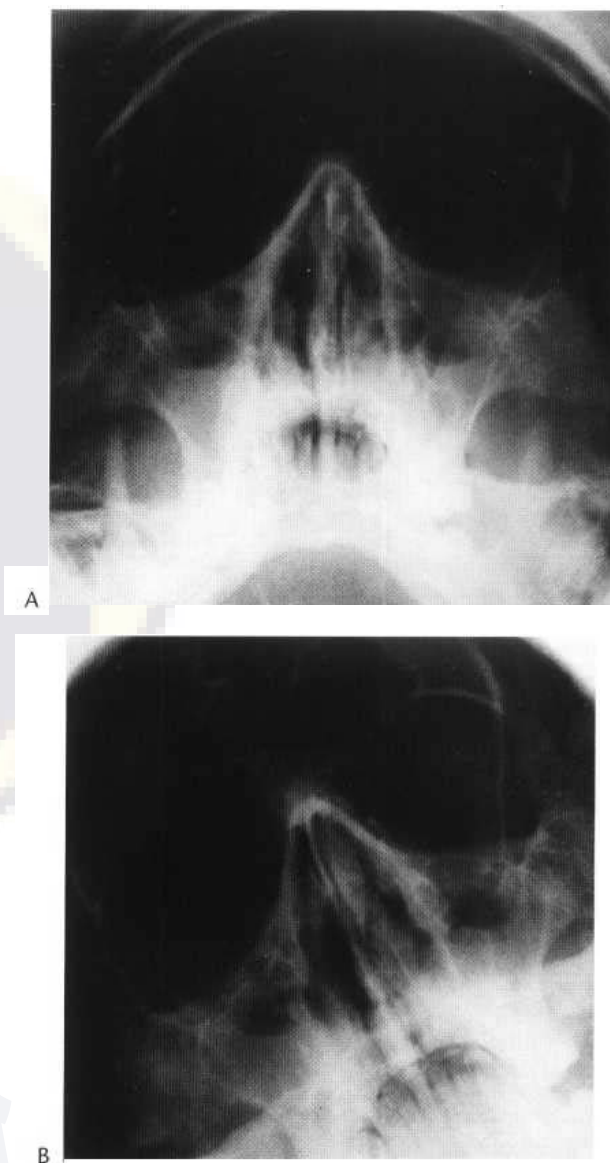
(A, B) Plain X-ray. Note opacification due to acute sinusitis and the fluid levels on tilted view (B).
